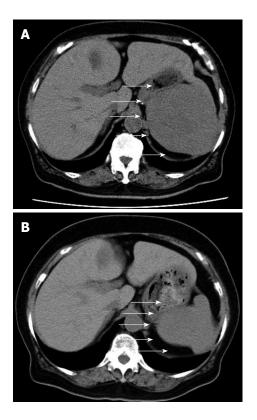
Abdominal computed tomography. A: Just before the operation; B: 1 year before the operation. Arrows show the splenic tumor.
